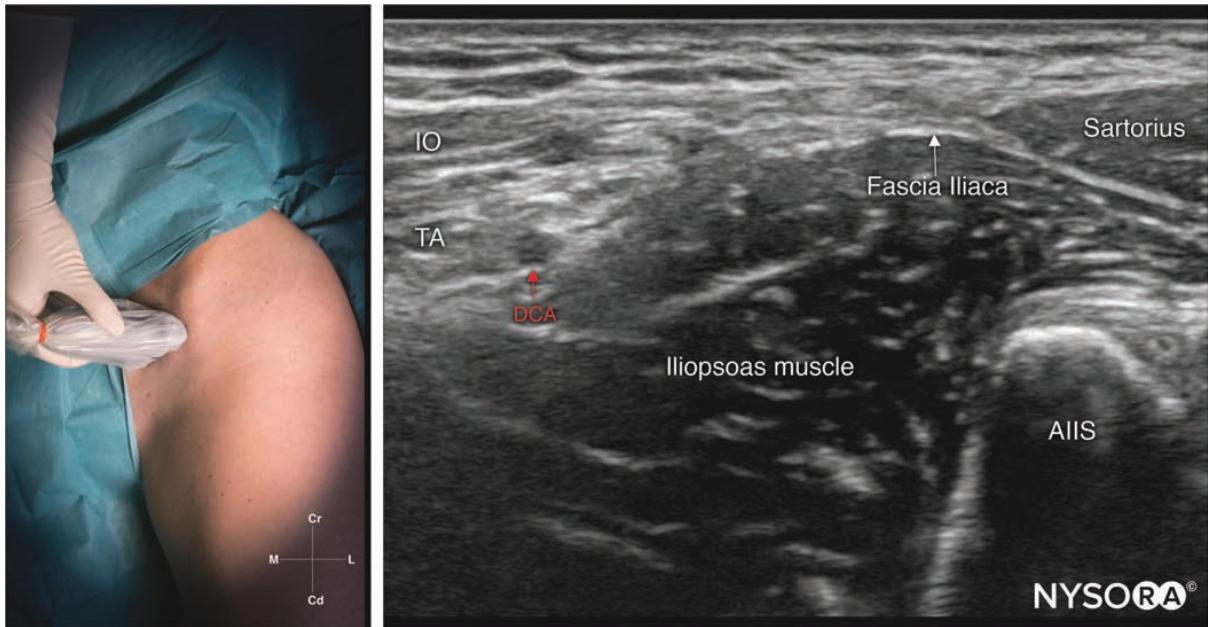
Transducer position and ultrasound image of a suprainguinal fascia iliaca block. IO, internal oblique muscle; TA, transversus abdominis muscle; DCA, deep circumflex artery; AIIS, anterior inferior iliac spine.
